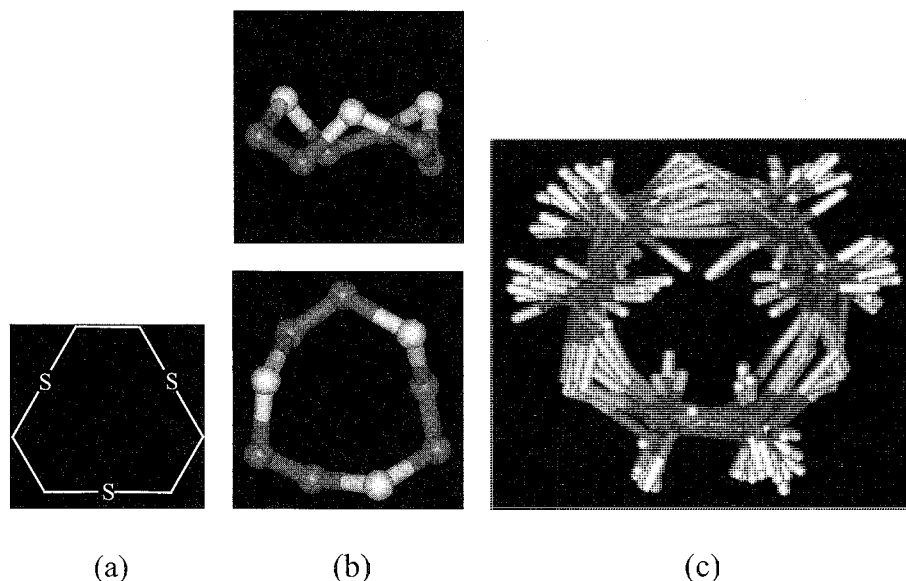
(a) Formula. (b) x-ray structure. and (c) calculated conformers of the 1,4,7-trithiacyclononane 9S3 using a systematic search. (View this art in color at www.dekker.com.)
